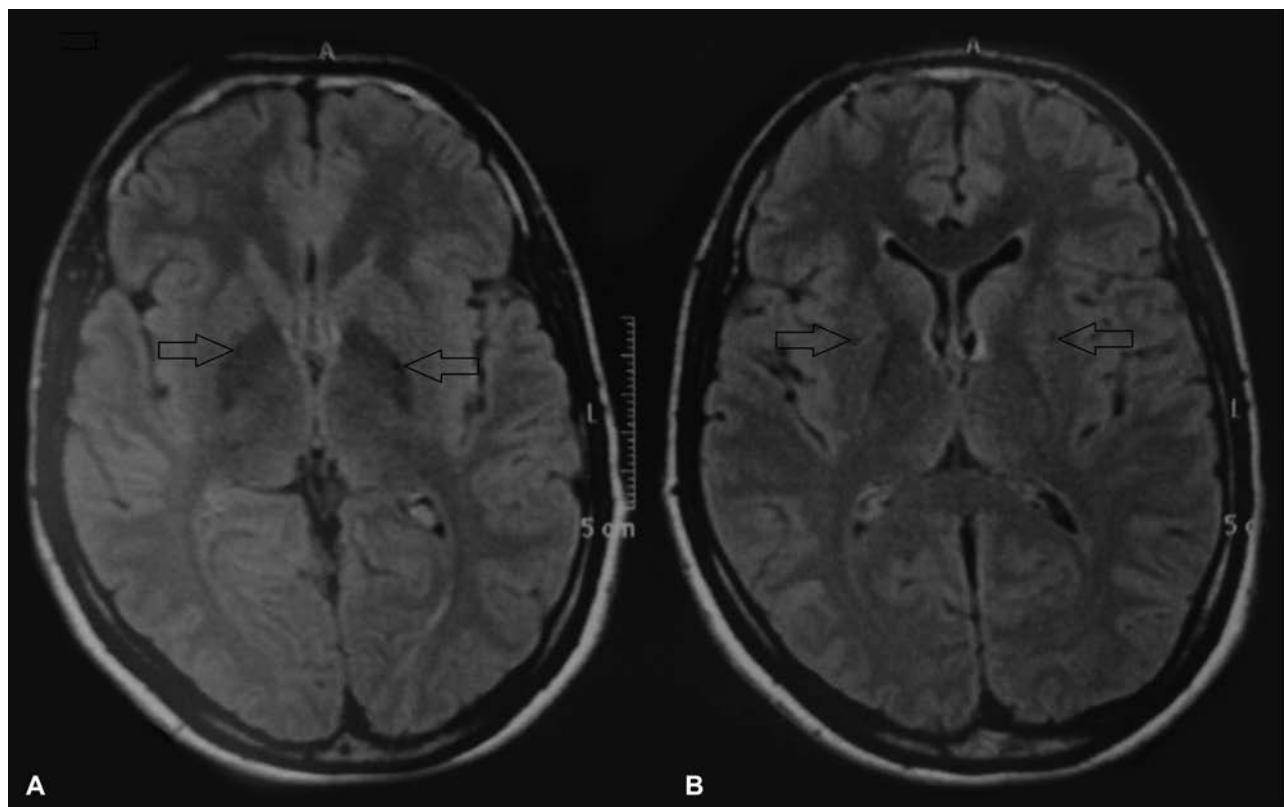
Cranial axial magnetic resonance imaging – Flair sequence. (A) Note the presence of bilateral hypointense points, indicated by the arrows, in the globus pallidus, corresponding to areas of post-traumatic brain injury gliosis. (B) Note the presence of bilateral hypointense points, indicated by the arrows, in the putamen, also corresponding to areas of post-traumatic brain injury gliosis.
